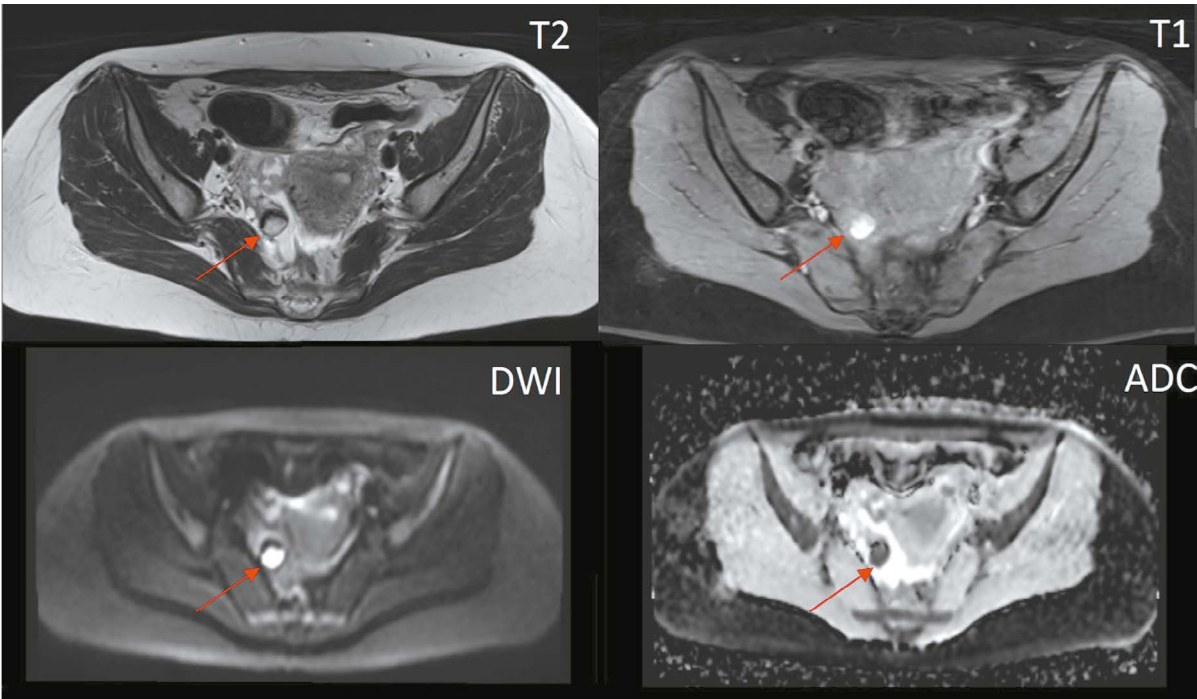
Pelvic magnetic resonance imaging (axial view). A single hemorrhagic cyst is observed in the stroma of the right ovary (O-RADS 1, red arrow).
